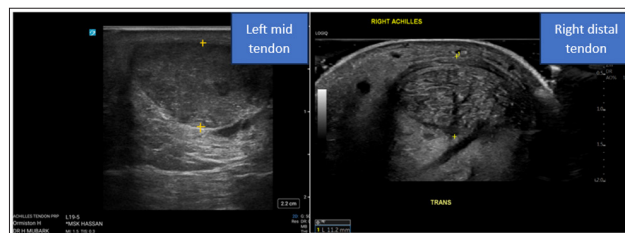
Pretreatment Ultrasound Demonstrating Thickening and Hyperaemia of the Right Distal and Left Mid-Portion Achilles Tendon
